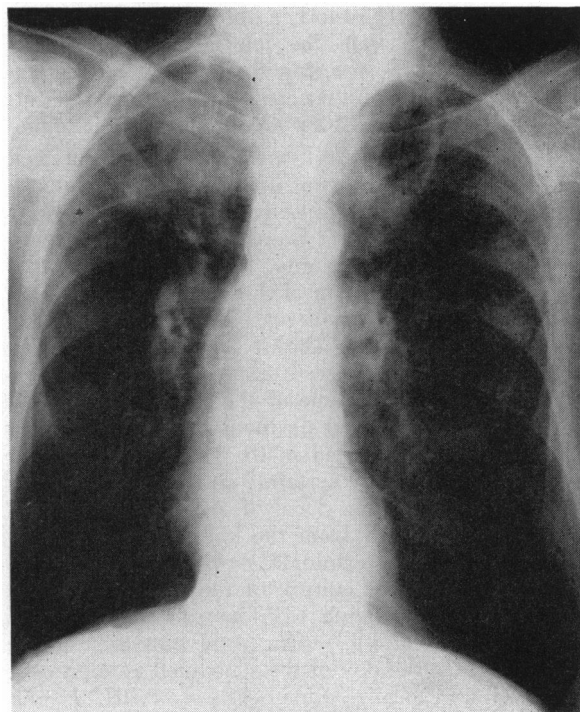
Posterior-anterior roentgenogram of chest showing lesions in the right and left upper lobes.
